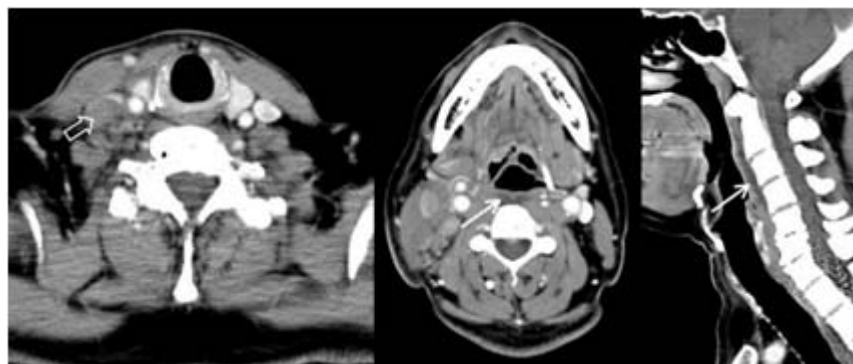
Retropharyngeal edema: Axial and sagittal enhanced CT scan showed low density at retropharyngeal space (arrow) with multiple cervical lymphadenopathy causing effacement of right internal jugular vein (open arrow).
